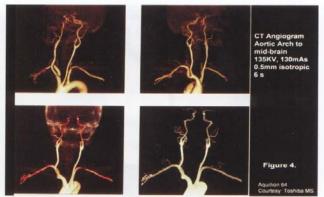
CT Angiogram showing the Aortic Arch to mid-brain using multi-slice CT (Scanning conditions: 135KV, 130mAs, 0.5mm isotropic 6 seconds, Aquillion 64, Courtesy: Toshiba Medical Systems)
